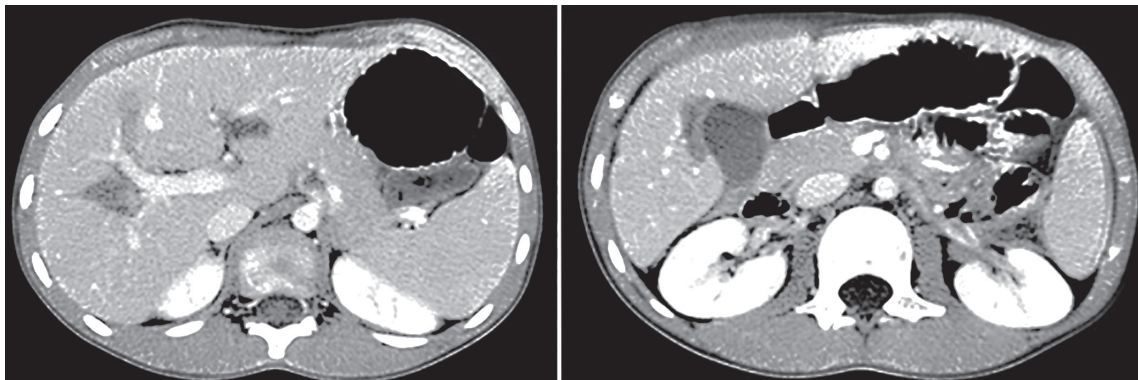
A computed tomography scan of the abdomen showing no liver hydatid cysts (left) with no pleural effusion (right) in the abdominal space of the patient after successful surgery.
